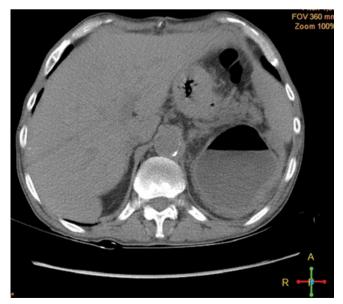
Axial computed tomography. Above the left kidney, there is a thick-walled fluid space with air-fluid level interpreted as a cyst of the tail of the pancreas
